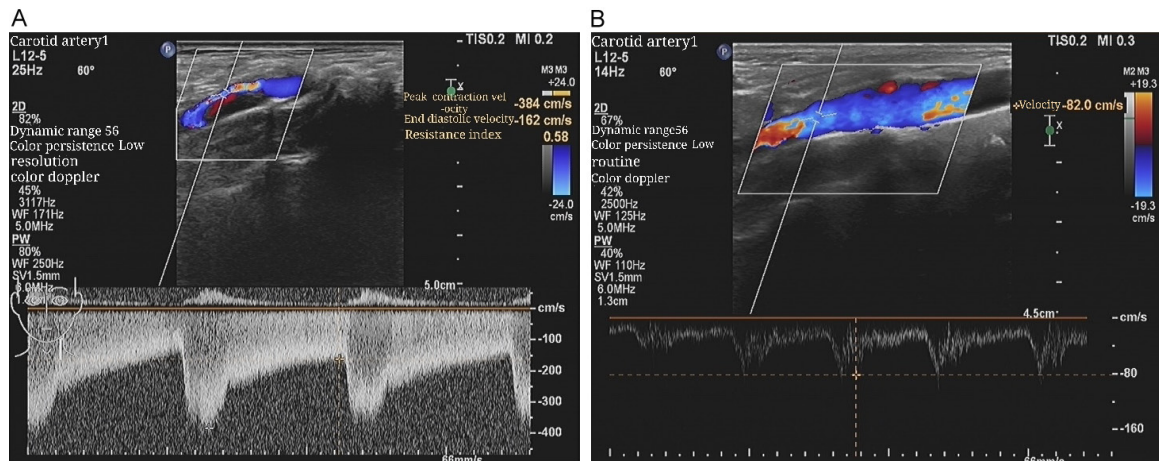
Doppler ultrasound induction of carotid artery pain in patients and normal people. A. Carotid artery cross-carotid Doppler color Doppler ultrasound B. Color Doppler ultrasound of carotid arteries in normal people.
